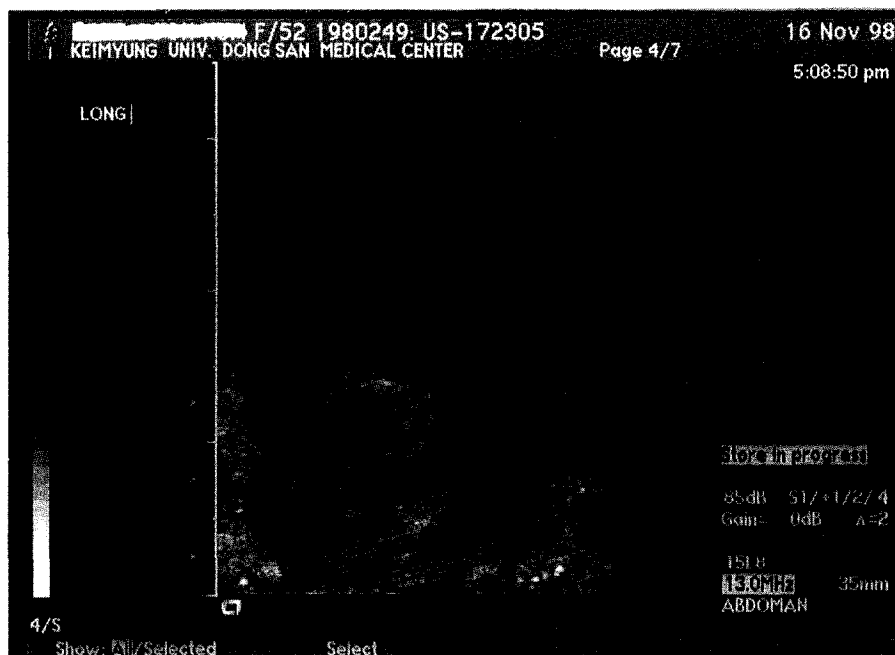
Transperineal ultrasonography reveals a well defined, round heterogeneous hypoechoic mass in the distal urethra.
